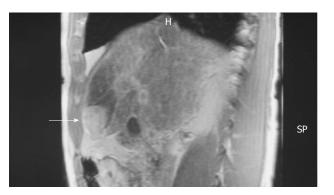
Magnetic resonance imaging showed a tumor-like lesion (arrow) and ischemia in segment 4 of the liver.
